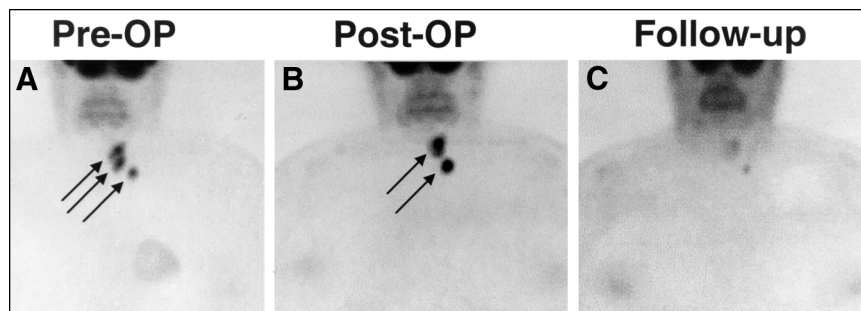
FDG-positive residual tumor and lymph node metastasis (arrows) in 57-y-old woman who presented after incomplete thyroidectomy and tumor resection of papillary thyroid cancer initially staged as pT4bN1Mx (A). FDG PET was performed to assess tumor extension and possible metastases before further surgery. Residual tumor masses were seen after additional surgery (B), and external irradiation yielded good response (C). After irradiation, hTg levels dropped from 24 to 1.5 $\mu\text{g/L}$. Images show maximum-intensity projections in anterior views.
